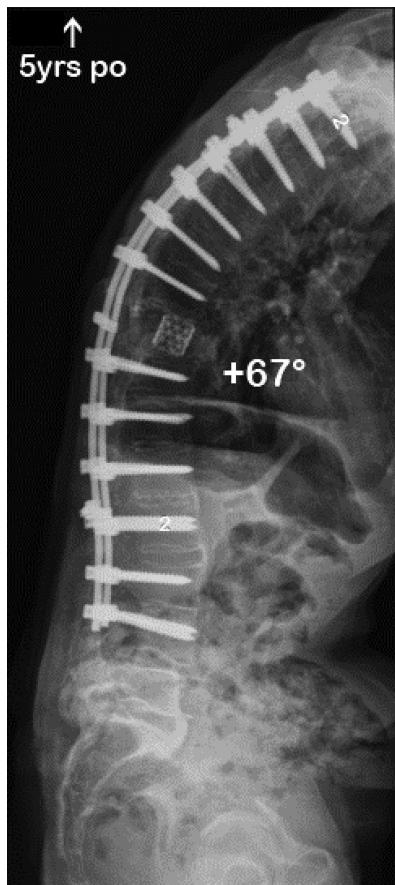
Five-year postoperative standing lateral radiograph showing kyphosis of 67°.
